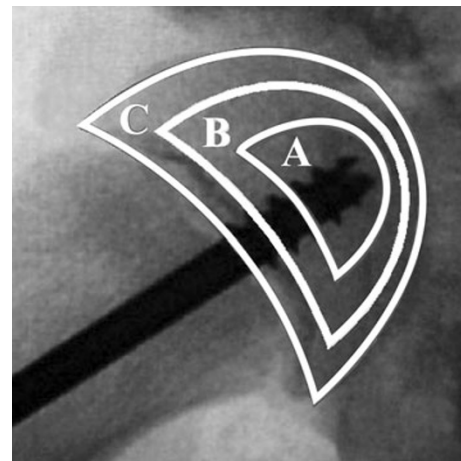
Radiograph of a femoral head showing the templates used to assess the accuracy of pinning. See text for details
